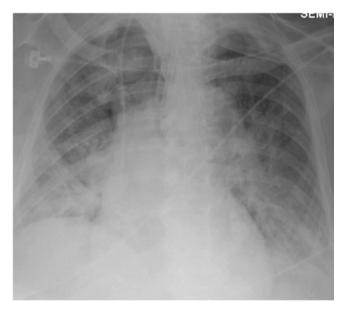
Chest X-ray on ICU day 5
